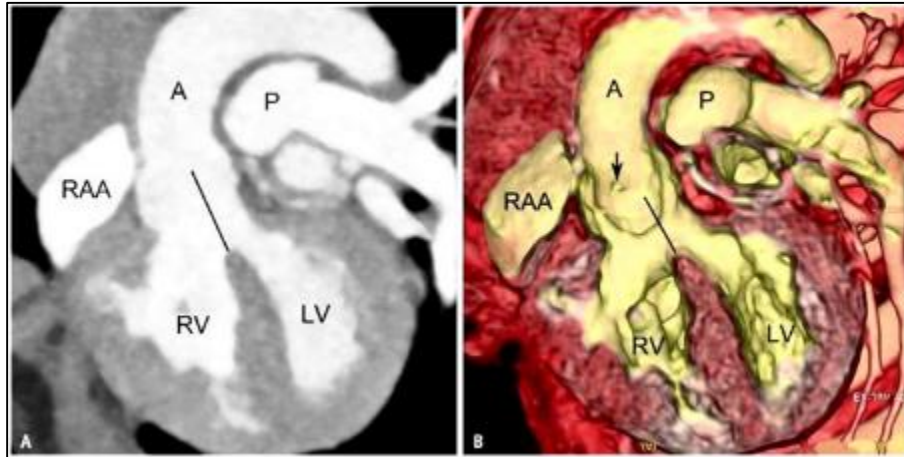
Practical 50% rule in a neonate with double outlet RV with subaortic ventricular septal defect and pulmonary stenosis. A, B. Long-axis CT image (A) and transparent-lumen volume-rendered CT image (B) show that a diameter > 50% of the annulus of the overriding aortic valve is connected to the morphologic RV based on an extension line of the ventricular septum. In clinical practice, measuring the diameter is more frequently used than the original method for measuring the circumference. The origin of the right coronary artery (arrow in B) was noted. A = aorta, LV = left ventricle, P = pulmonary artery, RAA = right atrial appendage, RV = right ventricle
